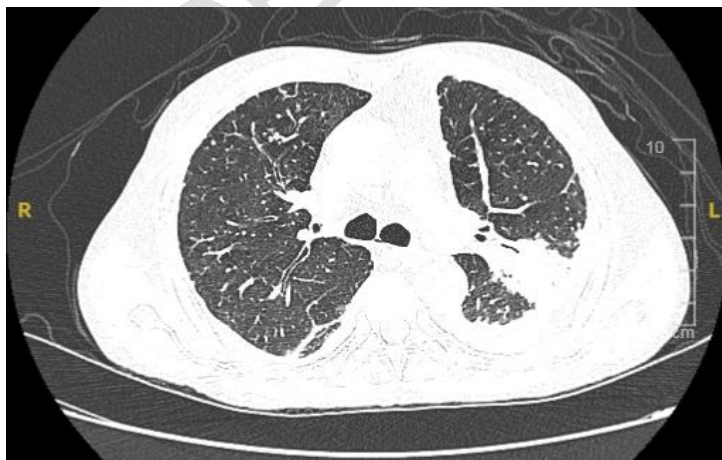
Radiographical findings of the patient chest
